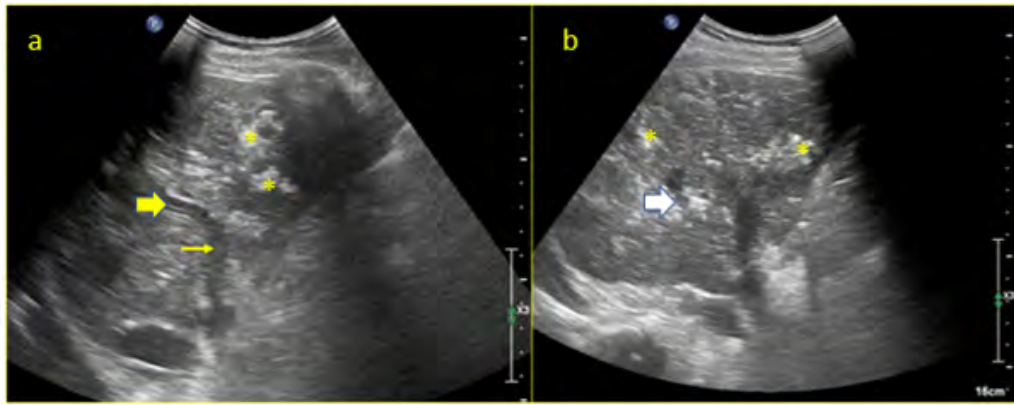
50/M (LAR-5) post LDLT . Doppler sonography on POD-5 (a, b) demonstrates gas echoes within the portal vein (yellow arrow), its right division (yellow block arrow), in segment VII branch(white block arrow) and in the liver parenchyma(Asterix) . Follow up scan on the next day showed complete resolution of the echoes.
